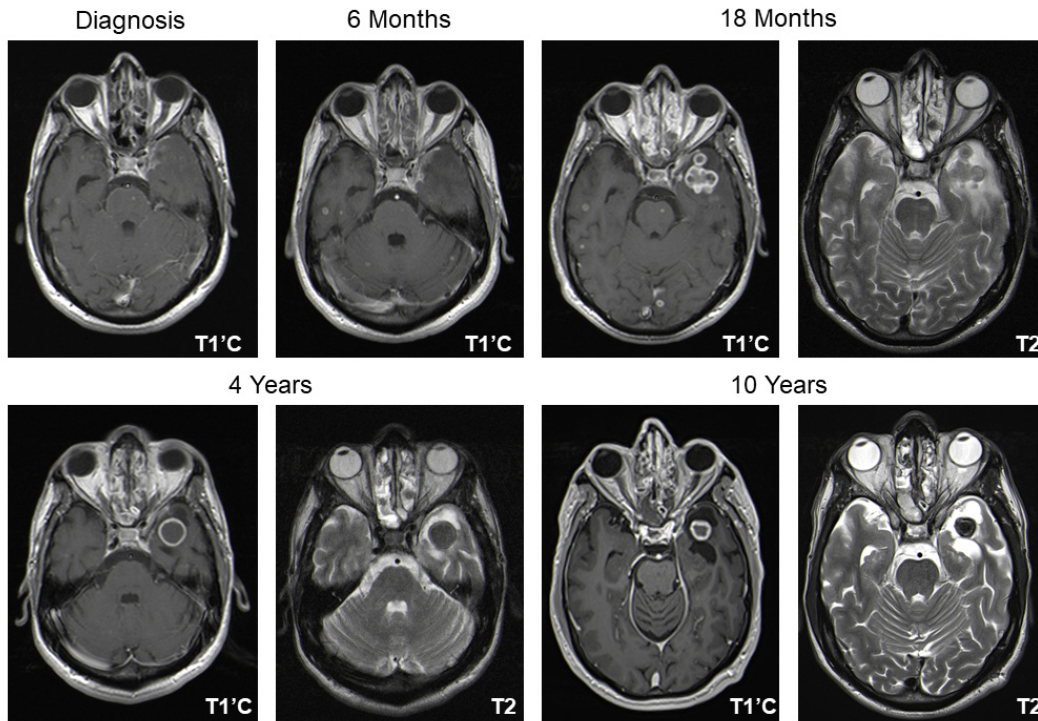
Serial magnetic resonance imaging of a patient with drug-susceptible central nervous system tuberculosis who received TB treatment for 4 years. Axial T1-weighted post-contrast (T1'C) images and T2-weighted (T2) images are shown. At diagnosis, a miliary pattern with focal meningeal enhancement of the left temporal lobe was noted, which persisted at 6-months follow-up. At 18 months, a lobulated rim-enhancing tuberculoma had developed in the left temporal lobe which was of mixed intensity on T2-weighted images with surrounding edema. Despite gradual reduction in lesion size and perilesional edema with associated atrophy, rim-enhancement persisted during the next 8.5 years of follow-up. Notably, the patient did not deteriorate clinically after cessation of TB treatment and the T2-signal of the lesion became increasingly hypointense (“T2-Black”) suggesting cure.
